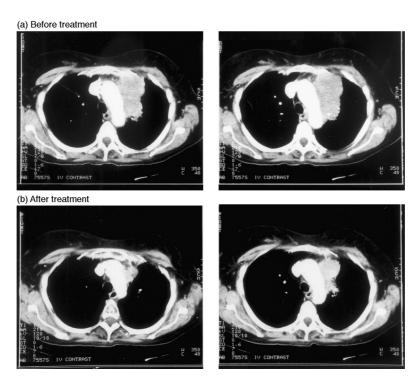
Computer tomography (CT) scan demonstrating response to BBR 2778.
